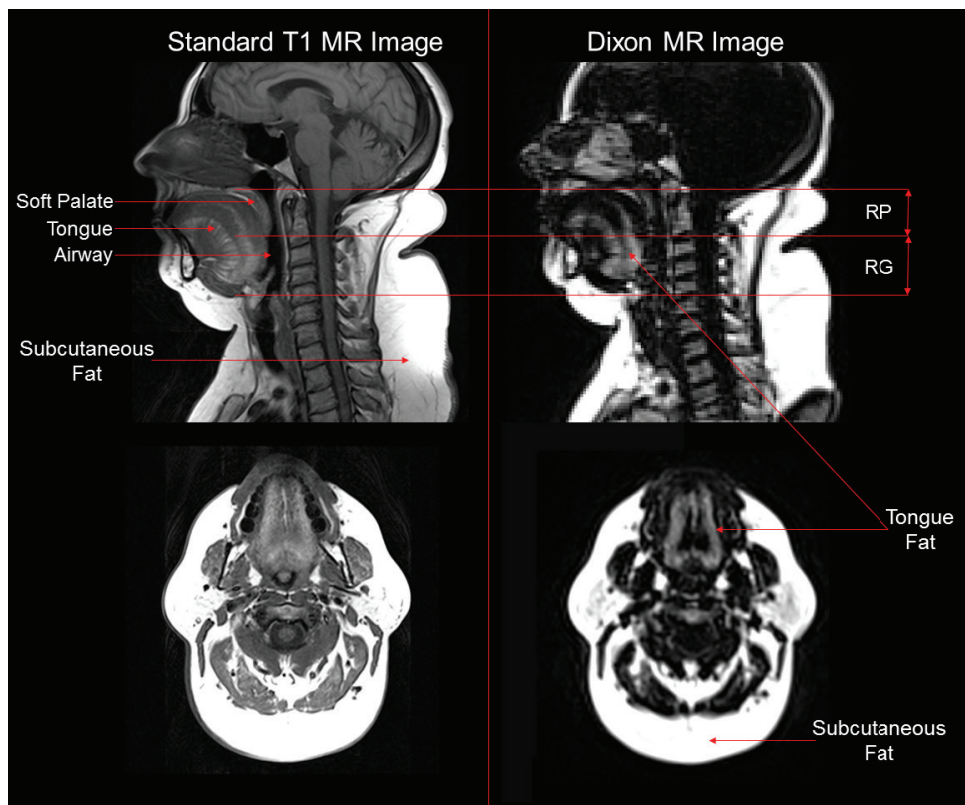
Comparison of tongue fat using standard T1-weighted spin echo MR imaging vs. fat-weighted Dixon MR imaging sequences in an apneic patient. Anatomic definitions of the upper airway regions are demonstrated: retropalatal (RP)—from level of hard palate to caudal margin of soft palate; and retroglossal (RG)—from caudal margin of soft palate to base of tongue. Soft palate, tongue, tongue fat, and airway are denoted with arrows. Both sagittal images are mid-sagittal and axial images are shown at same level of (mid) tongue. Note that fat deposits in tongue are more easily visualized using Dixon MR imaging sequence than the spin echo sequence.
